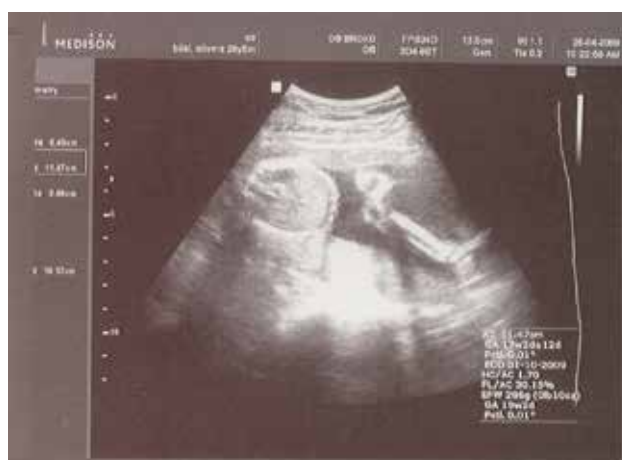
Ultrasound examination: gestational age 116/7 gw; FI/AC 0.30; asymmetric IUGR (3 weeks); normal ultrasound morphology of placental tissue and amniotic fluid
